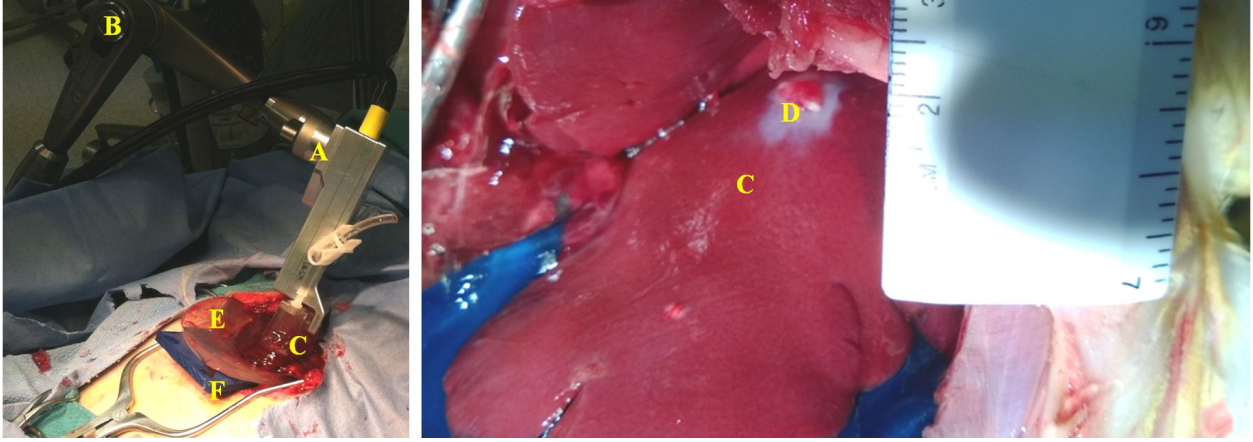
Experimental setup for focused and unfocused ultrasound exposures of *in vivo* rabbit liver. Image-ablate arrays (A) were held by a three-dimensional positioning arm (B). The liver lobe (C) with implanted VX2 tumor (D) was placed on an acoustic gel coupling pad (E) and/or acoustic absorber pad (F) before performing imaging and thermal ablation.
